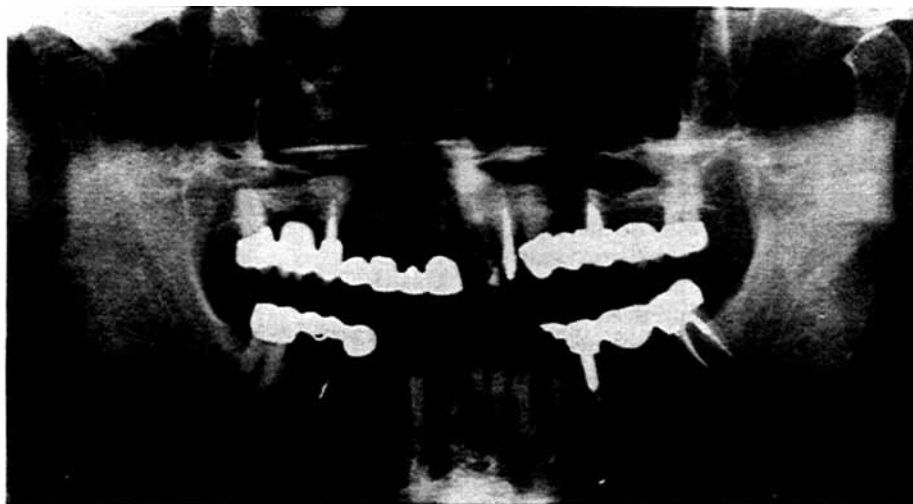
Panoramic radiograph showing flattening of the left condyle.
